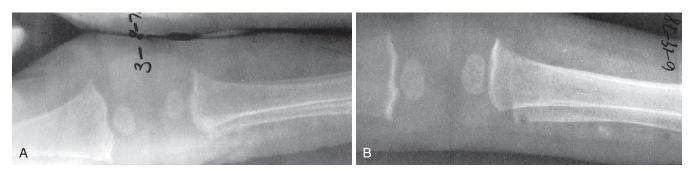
Copper deficiency: A, Radiograph of a child with copper deficiency reveals irregular epiphyses with spur formation, cloaking of metaphyses, periosteal new bone formation, and osteoporosis. B, After 3 months of intravenous copper, the child demonstrates healing of the metaphyses.
